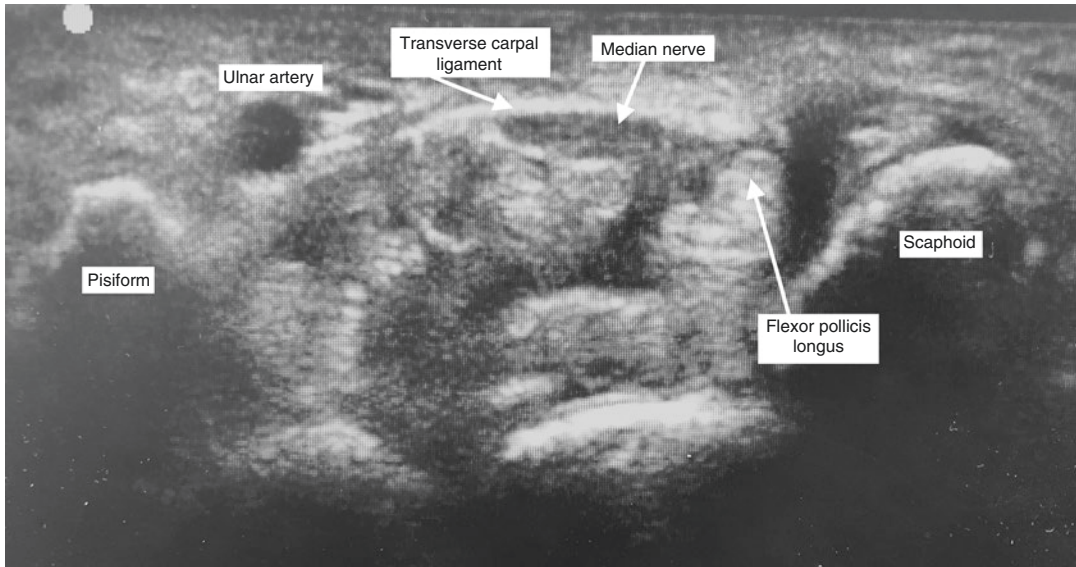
Ultrasound image demonstrating the view obtained from Fig. 3.1
